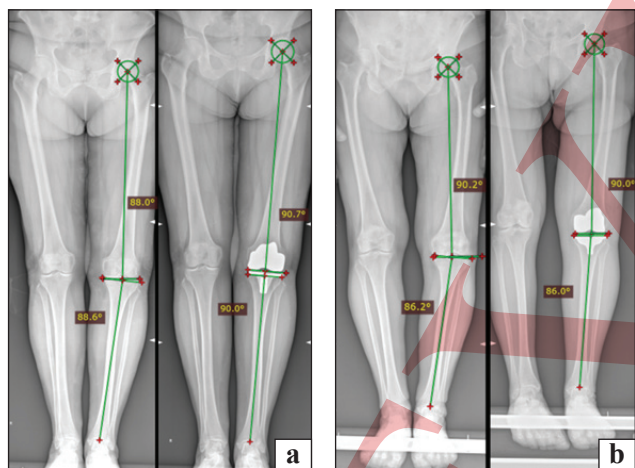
Radiography findings before and after the installation of the endoprosthesis components according to the preoperative planning (a — mechanical alignment, b — kinematic)
